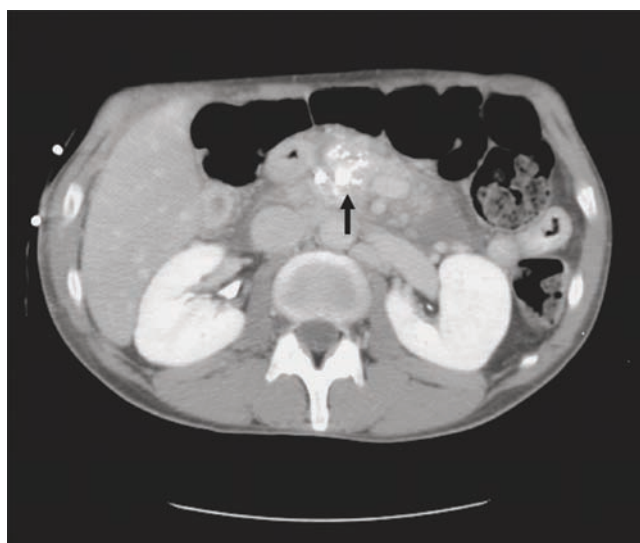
Axial cross-sectional abdominal CT demonstrating enlargement and dense calcifications (arrow) in the pancreatic head in alcohol-associated chronic pancreatitis.
